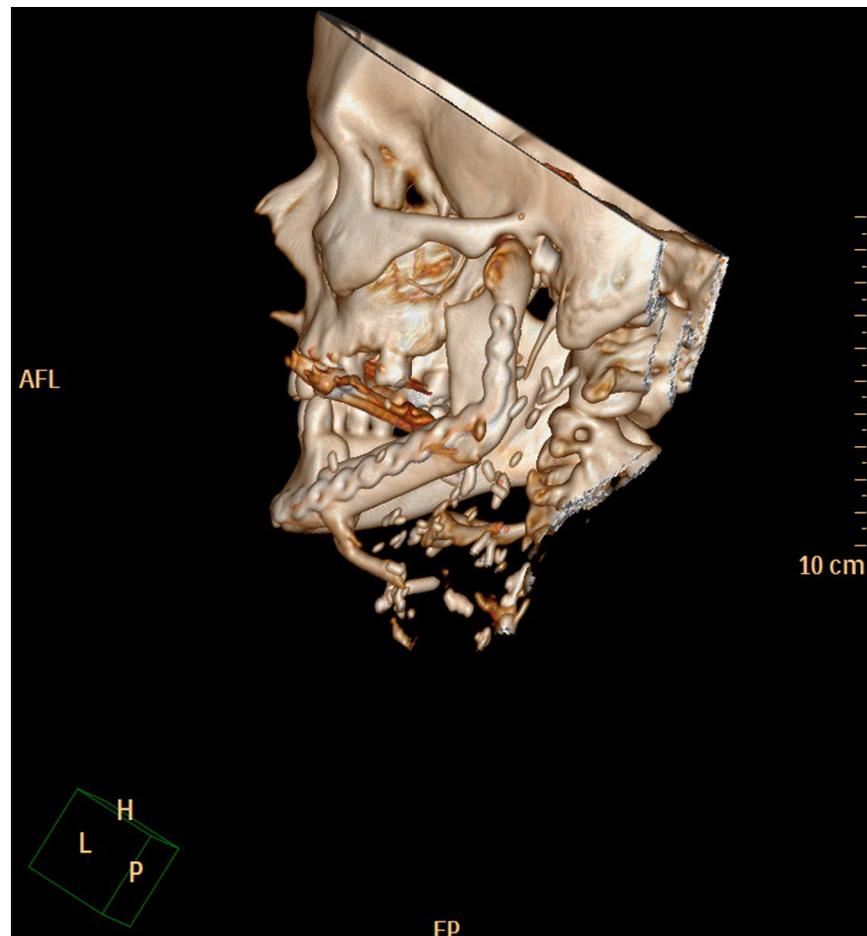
Three-dimensional computed tomographic scan showing the left inferior pedicle extending towards the hyoid bone.
